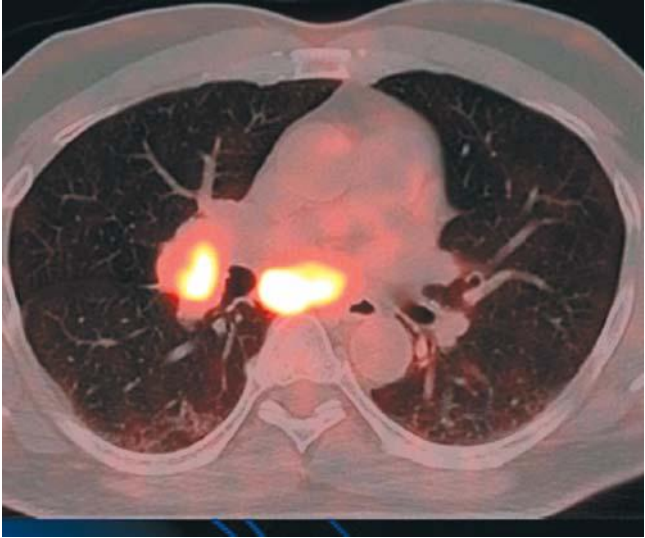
Axial PET image showing the FDG intake for a lung tumor. (Courtesy of Radiation Oncology Department, Lahey Clinic.)
